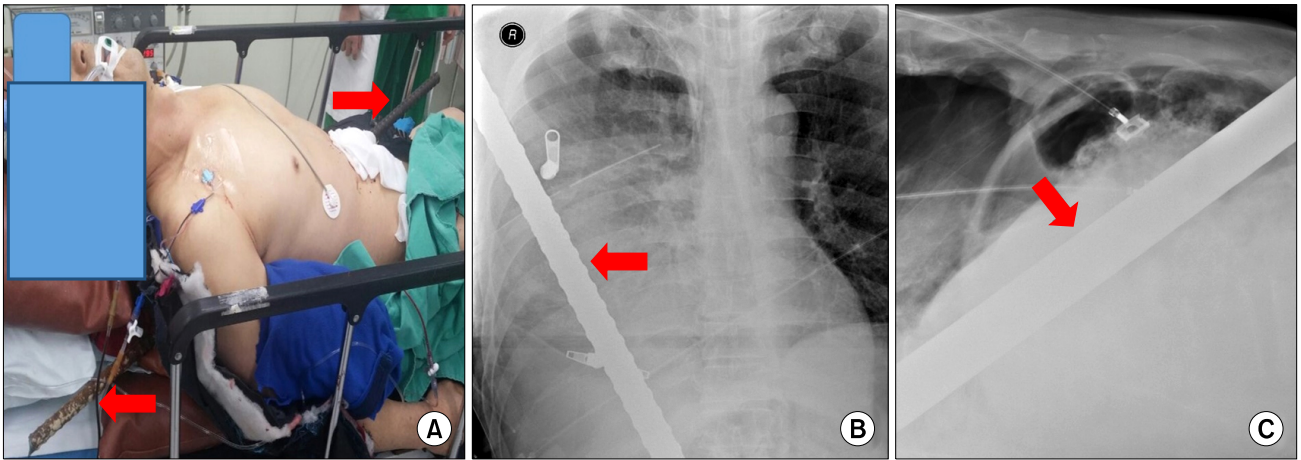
(A) The patient was placed in a semi-reclining position. The steel bar penetrated his torso from the epigastrium to the right scapula (arrows). (B, C) Chest X-ray taken after tube thoracostomy. The impaling object was visible (arrows) in the right chest (B) and abdomen (C).
